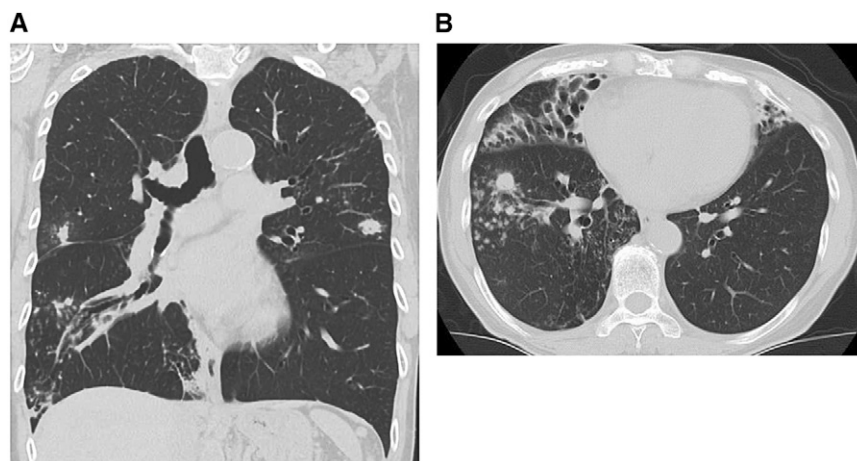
Representative coronal (A) and axial (B) chest computed tomography images showing the infection before onset of treatment.
